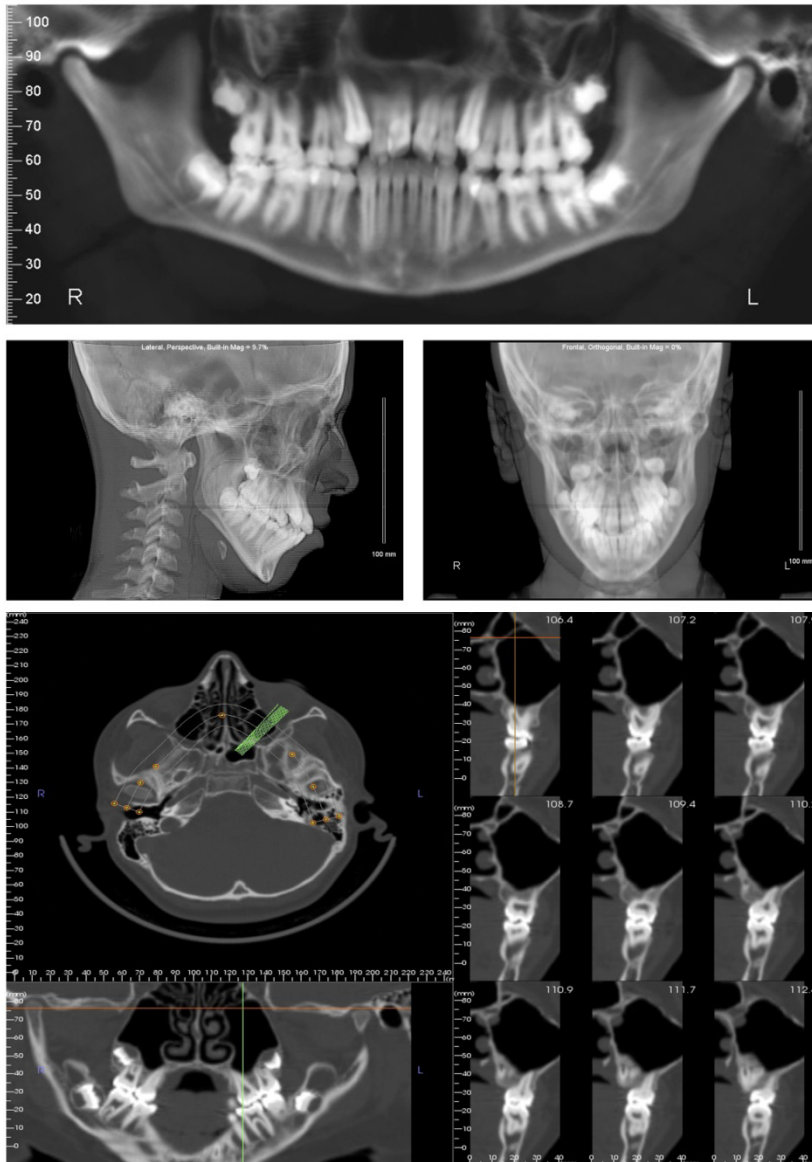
CBCT data can be easily reconstructed into traditional panoramic, lateral, or postero-anterior cephalometric images, as well as cross section views. In this way, the clinician can get more information from the scan than from multiple 2D radiographs with less radiation exposure. Images created by the Dolphin and InVivoDental softwares from a single CBCT scan.
